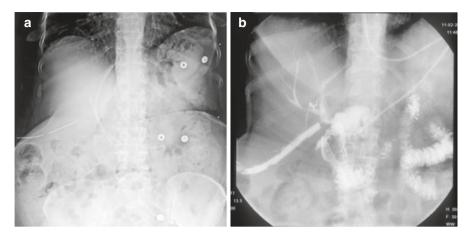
Endoscopic intervention in EBF. (a) Right hepatic duct injury during extended cholecystectomy requiring multiple stents noted on a plain X-ray abdomen. (b) Placement of ENBD for control as seen on the ENBD gram. The fistula healed in 2 weeks
